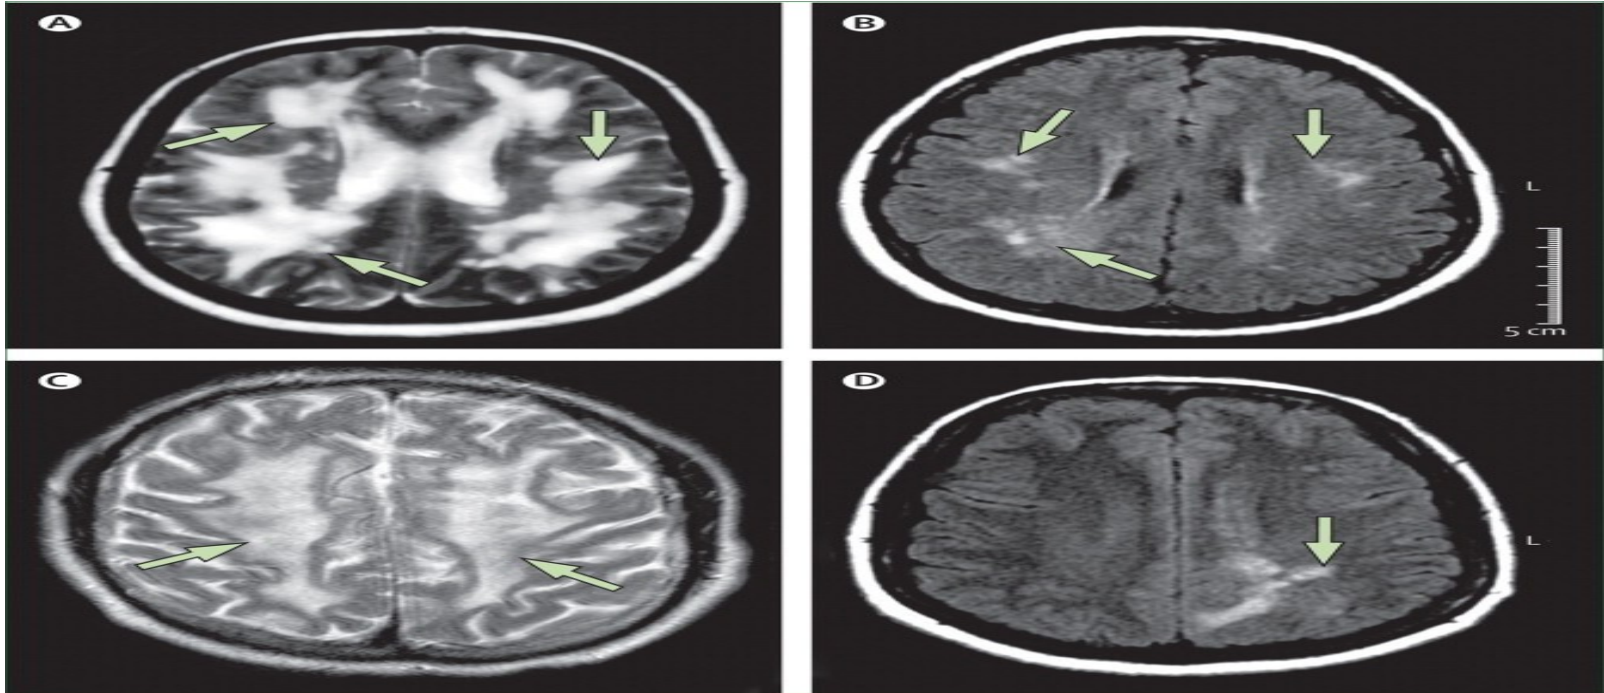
MRI in four patients with gluten encephalopathy. The extent and variability of white matter abnormalities caused by gluten sensitivity can be seen in these four patients (A–D). A and C show diffuse white matter changes, whereas B and D show more f...
